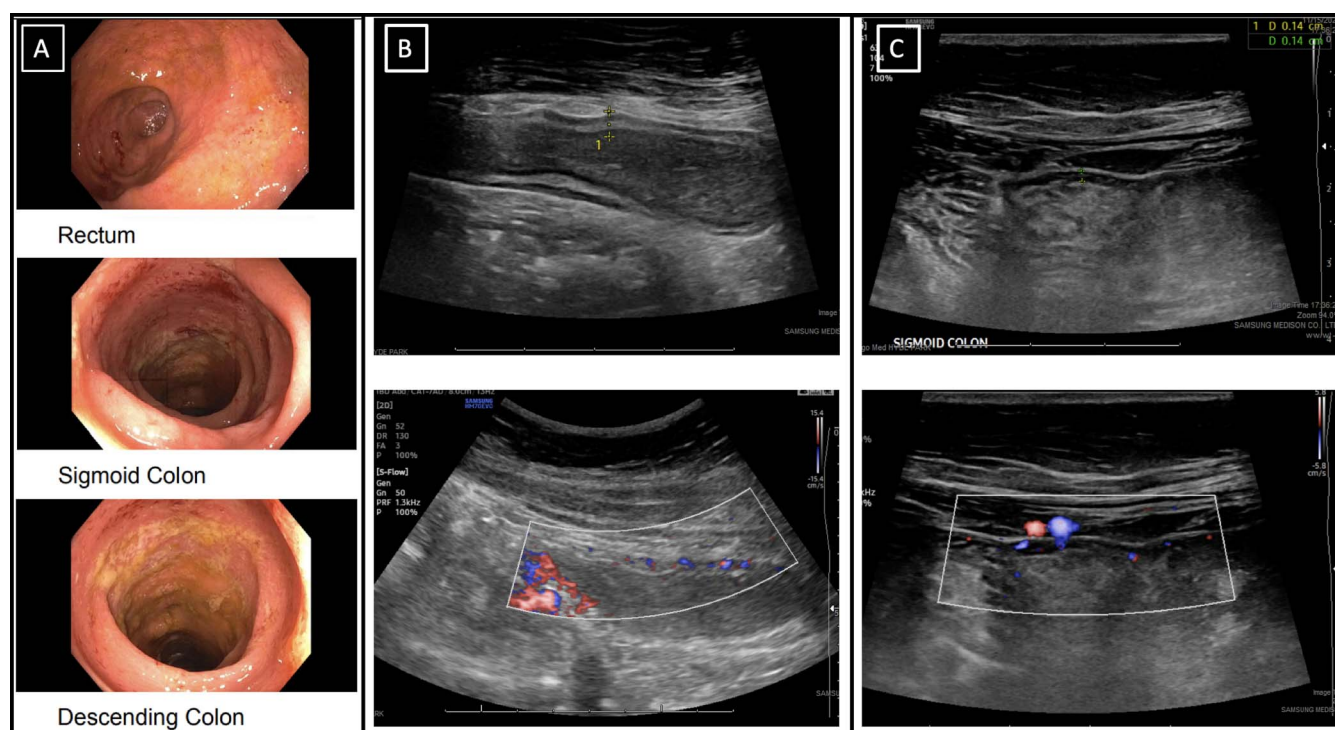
Baseline colonoscopy before UPA (A). IUS (intestinal ultrasound) before UPA showing increased bowel wall thickness and hyperemia consistent with inflammation (B). IUS at day 3 of UPA with improved bowel wall thickness and hyperemia (C). UPA, upadacitinib.
